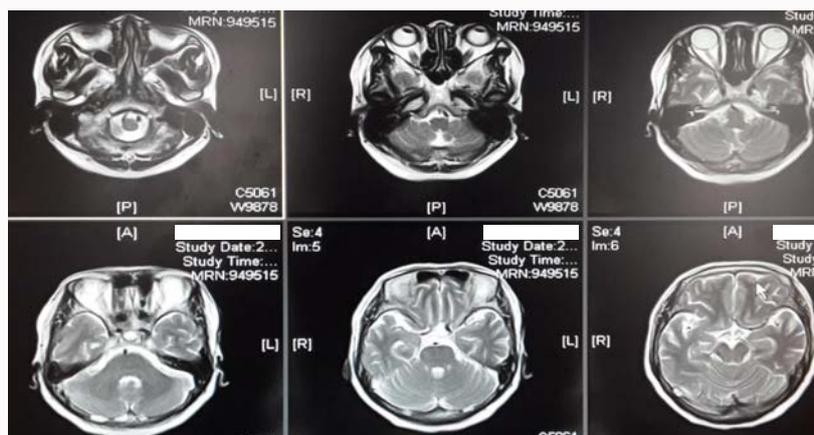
MRI demonstrated the brain and eyes were normal.
